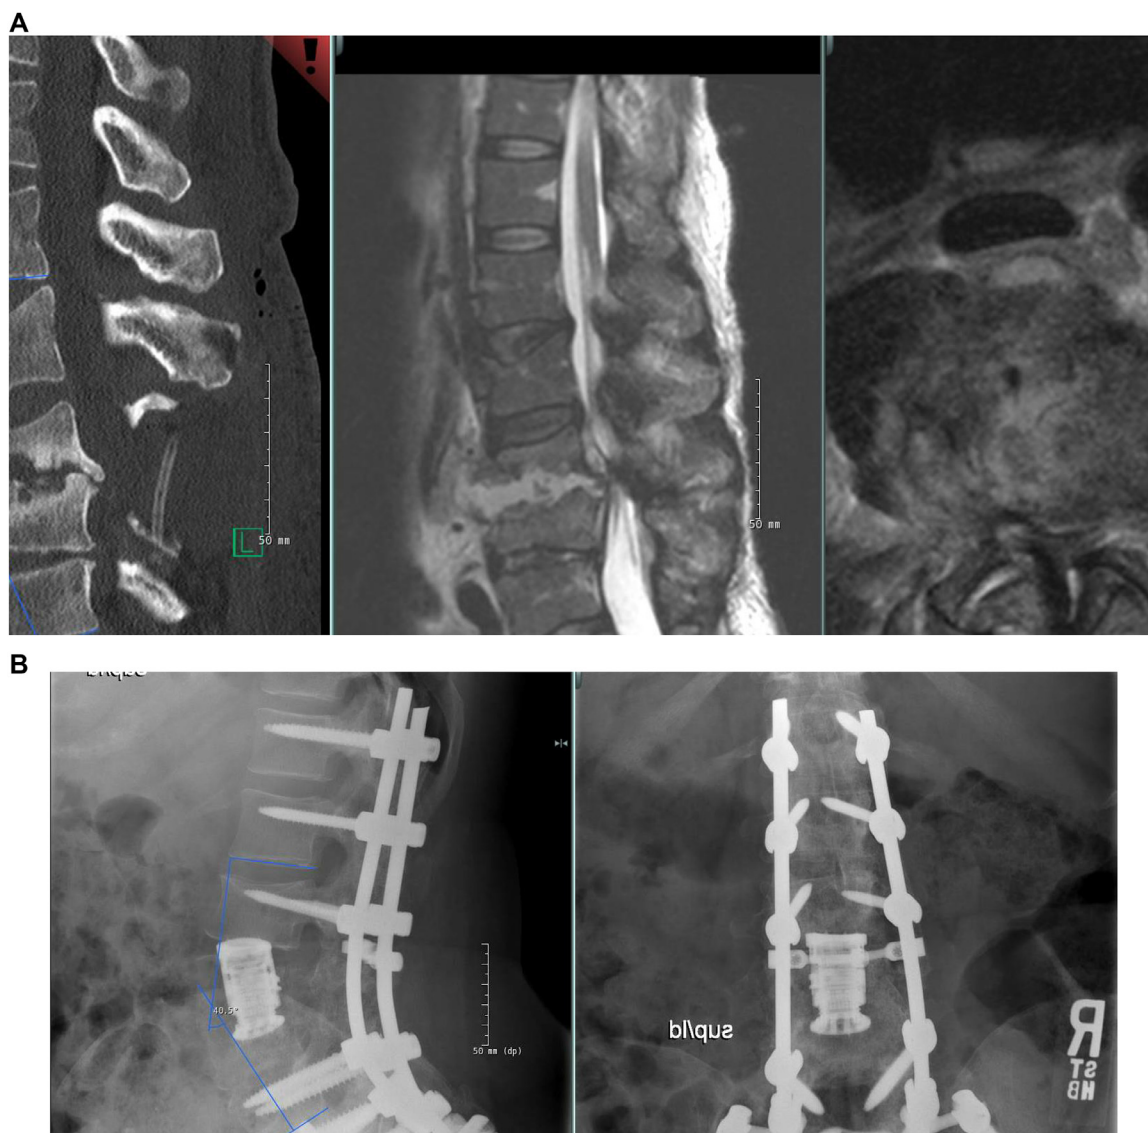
A 52-year-old female presented with acute right lower extremity weakness. She has a history of human immunodeficiency virus and intravenous drug abuse. She underwent an emergent lumbar laminectomy and decompression. Following the surgery, she had improvement in her right leg weakness, but was still unable to ambulate due to pain. She then underwent an L3 corpectomy, L4 vertebral column resection, L5–S1 transforaminal interbody fusion, placement of an expandable intervertebral titanium spacer, and a T12–pelvis posterior spinal fusion. Following the second surgery, she was able to ambulate and had significant improvement in her pain. (A) Preoperative computed tomography (lateral) and magnetic resonance imaging (T1-weighted sagittal and axial) demonstrates L3–L4 osteomyelitis/discitis with extensive osseous destruction and epidural abscess as well as L3–L4 spondylolisthesis. (B) Follow-up AP and lateral radiographs demonstrate improvement in the focal segmental deformity.
